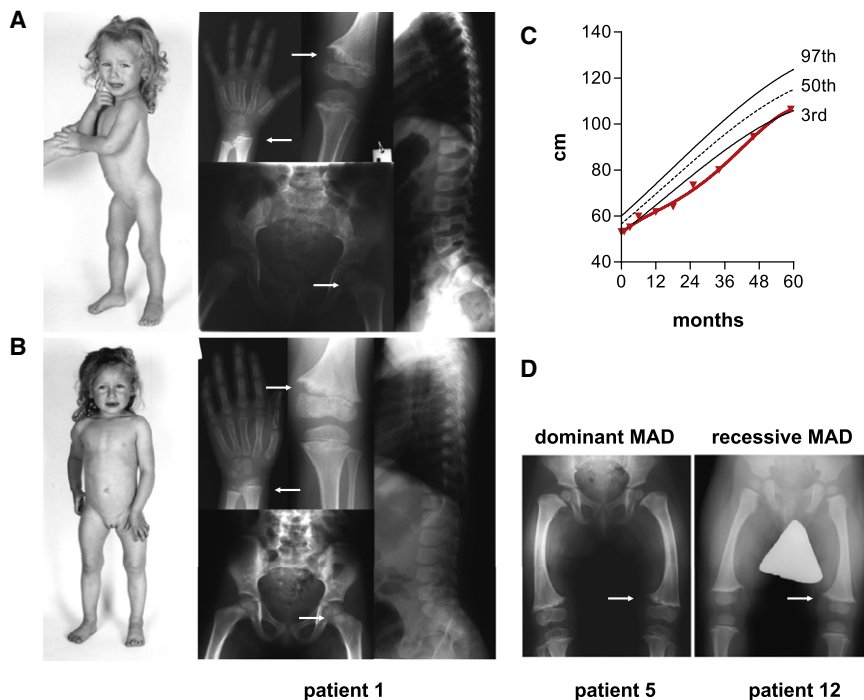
Clinical and Radiographic Presentation of MAD
